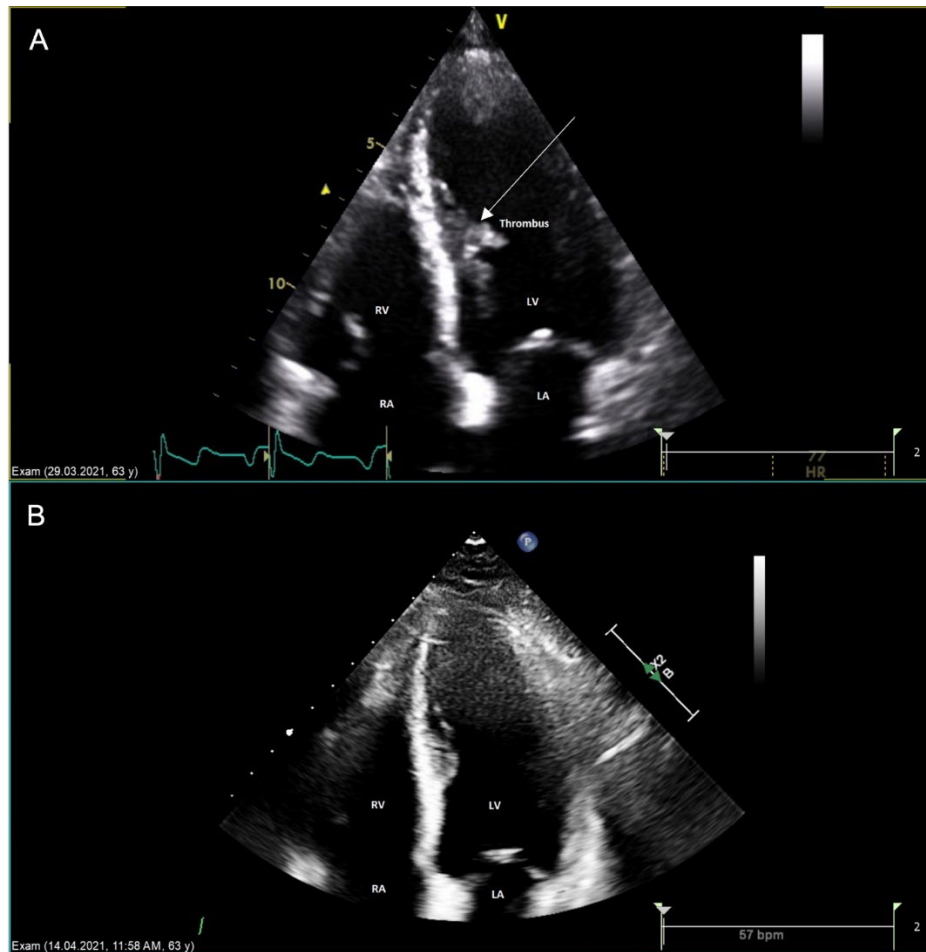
Trans-thoracic echocardiogram (TTE) four-chamber view in diastolic phase images of Case 2 showing (A) thrombi (white arrow) attached to the mid inferoseptal wall and (B) resolution of thrombi post treatment on repeat TTE 2 weeks later.
